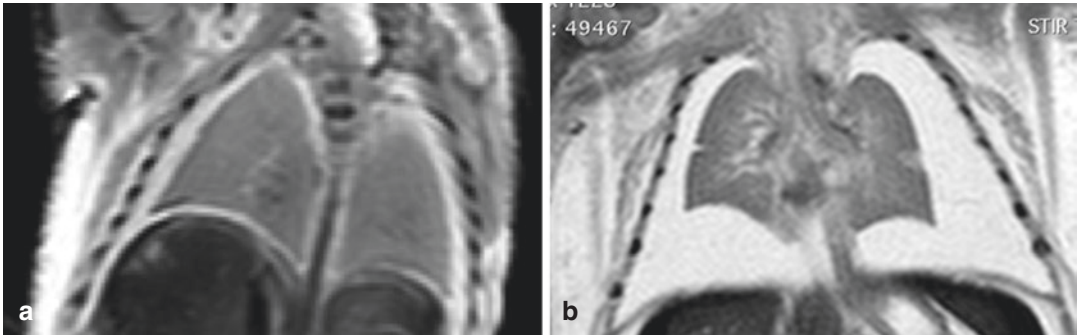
Post-mortem MRI coronal T2w TSE. Comparison of two different foetuses centred on the thorax. In (b) is clearly visible partial collapse of both lungs associated with pleural effusion
